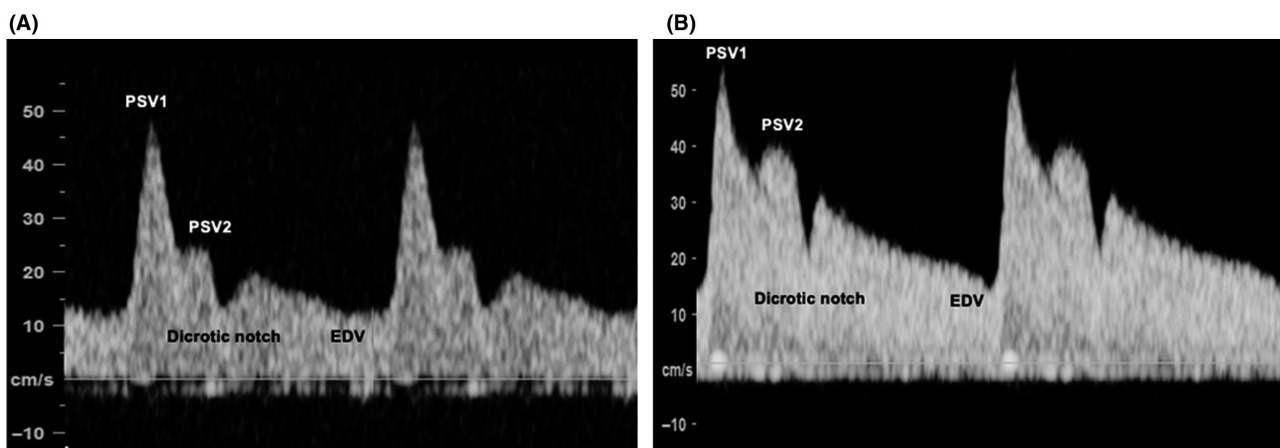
Doppler sonogram with demonstration of the ophthalmic artery waveform by pulse-wave Doppler. The first systolic velocity peak (PSV1), second systolic velocity peak (PSV2), dicrotic notch and the end-diastolic velocity (EDV) are shown in: (A) a woman with no hypertensive disease in pregnancy, and (B) a woman with pre-eclampsia. Note that the PSV2 is higher in pre-eclampsia, compared with normotensive women
